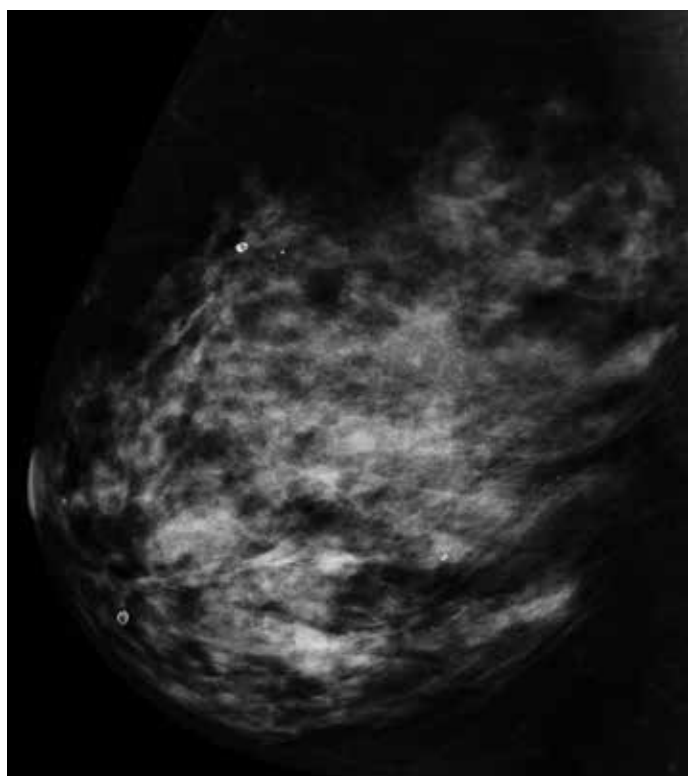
Example of BIRADS D mammography density, no abnormality perceived on standard 2D mammogram or ultrasound. BIRADS D - The breasts are extremely dense, which lowers the sensitivity of mammography.
